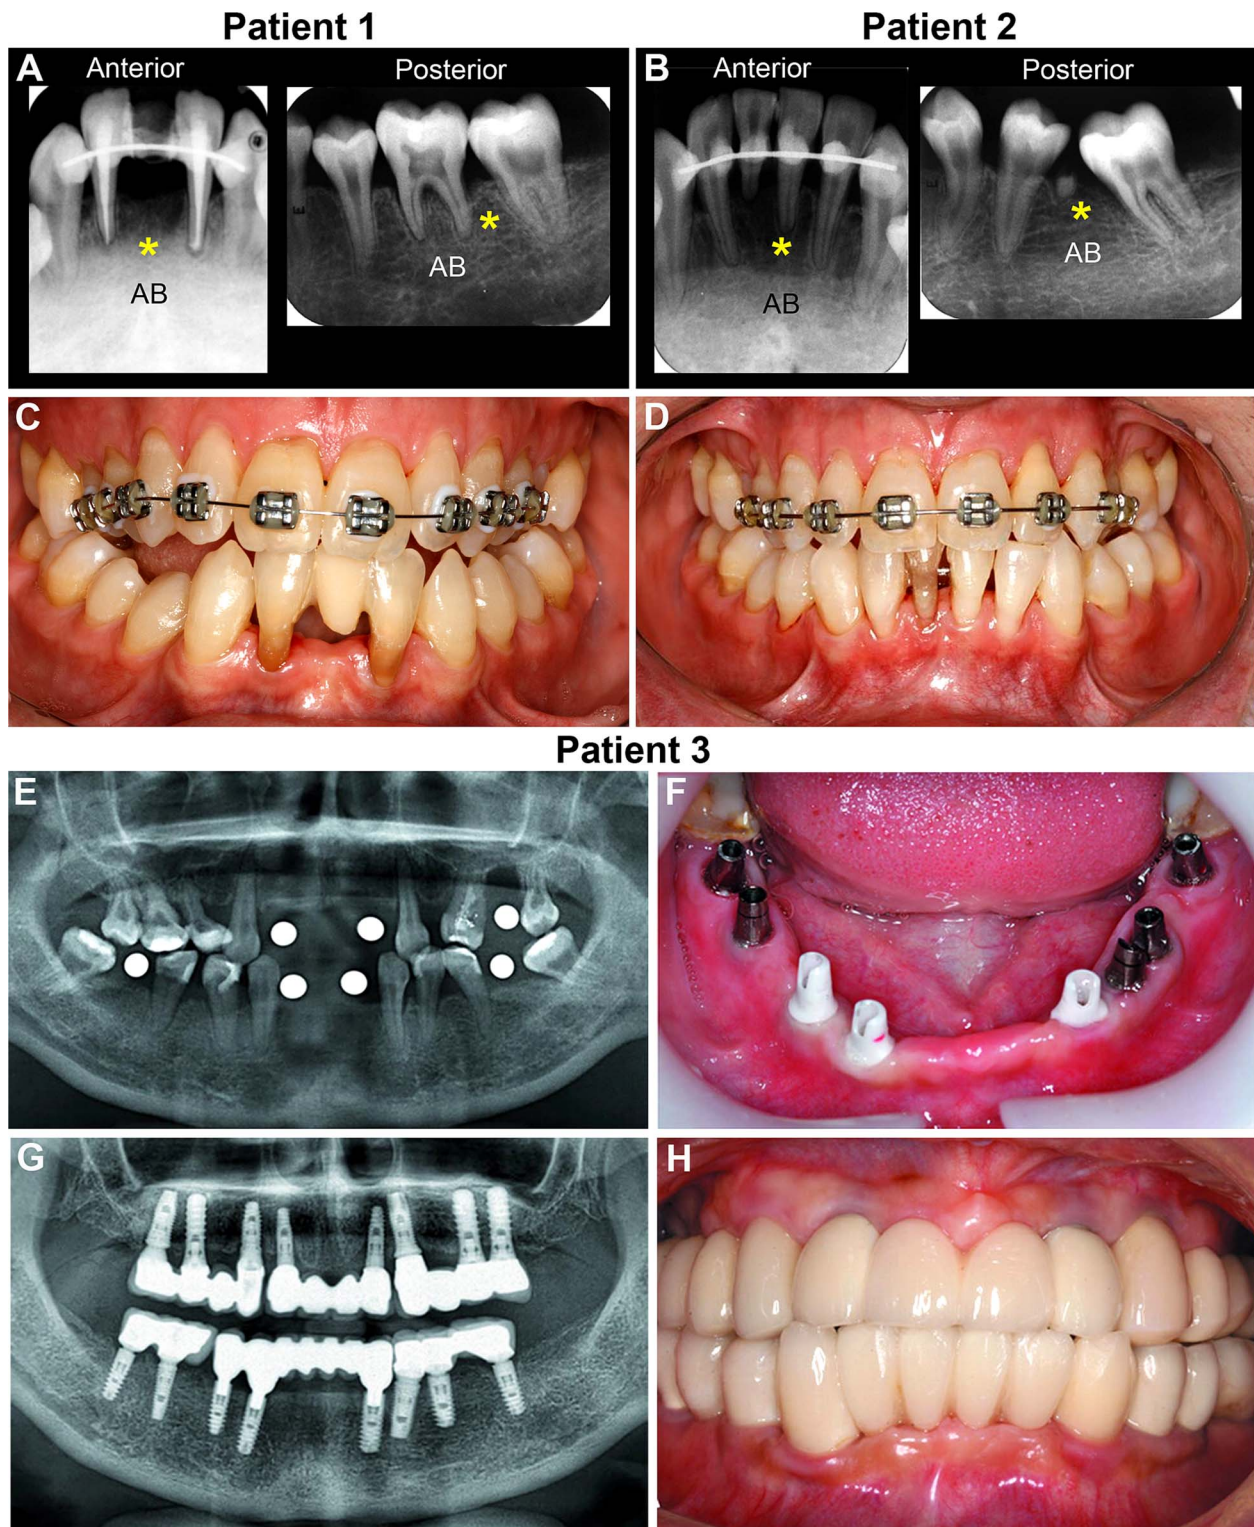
Dental treatment of individuals with hypophosphatasia. Patients 1 and 2 in (A-D) received periodontal and orthodontic treatment. (A, B) Periapical radiographs of anterior and posterior teeth of 20-yr-old twin male patients showing severe reduction in alveolar bone (AB) height (stars), wide pulp chambers, and short tooth roots with some abnormal shapes. (C, D) Photographs of the same patients taken after periodontal treatment and during the active phase of orthodontic treatment. Patient 3 in (E-H) received prosthodontic treatment. (E) Panoramic radiograph showing extensive tooth loss in a 24-yr-old female with HPP (edentulous regions indicated by circles). (F) Placement of abutments for dental implants following mandibular tooth extraction. (G) Alveolar bone levels appear stable at 7-yr follow-up and (H) the patient remains satisfied with the prosthetic rehabilitation. Images in (A-F) reproduced with permission from Rodrigues et al, clinical correlate: Case study of identical twins with cementum and periodontal defects resulting from odontohypophosphatasia. In: Mineralized tissues in oral and craniofacial science: Biological principles and clinical correlates, Wiley, 2012. Images in (E-H) reproduced with permission from Yang et al., *J Prosthodont* 30(9), 2021.
